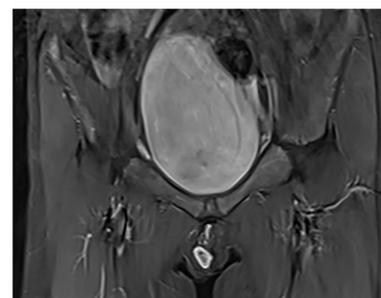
MRI with contrast demonstrating right labial LIC of venous malformation.
